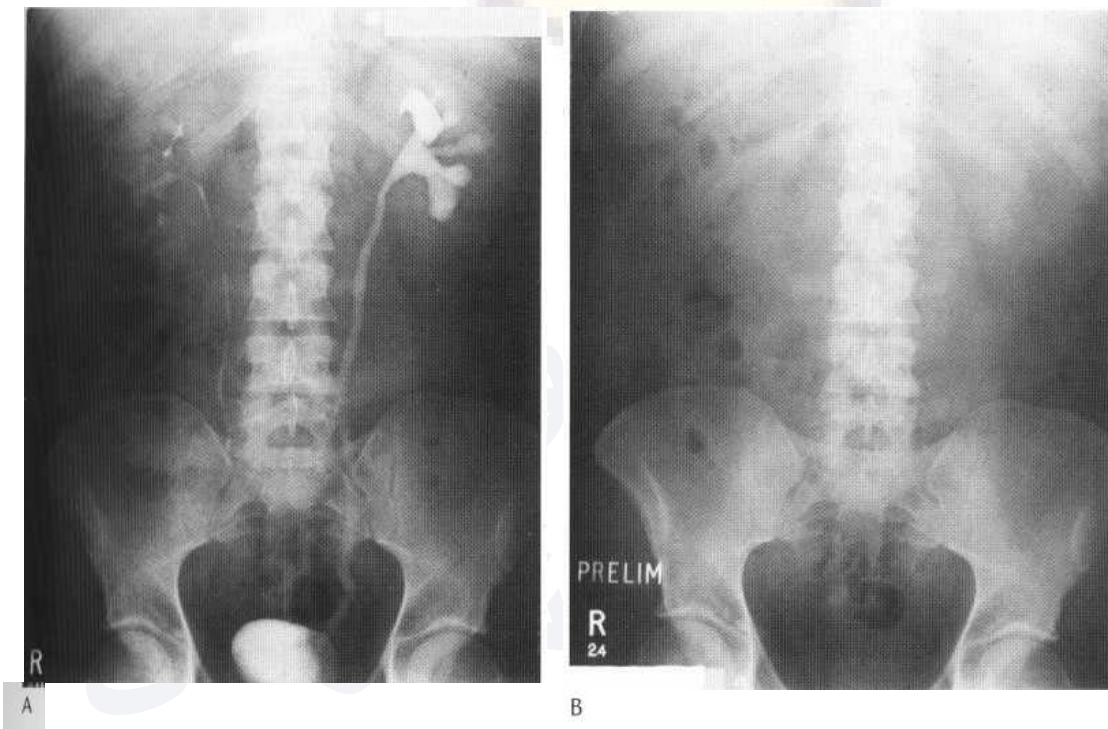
Full length film from an IVU series (A) showing stasis and mild fullness in the left ureter and considerable oedema around the vesicoureteric junction due to a small calculus visible on the plain film (B).
